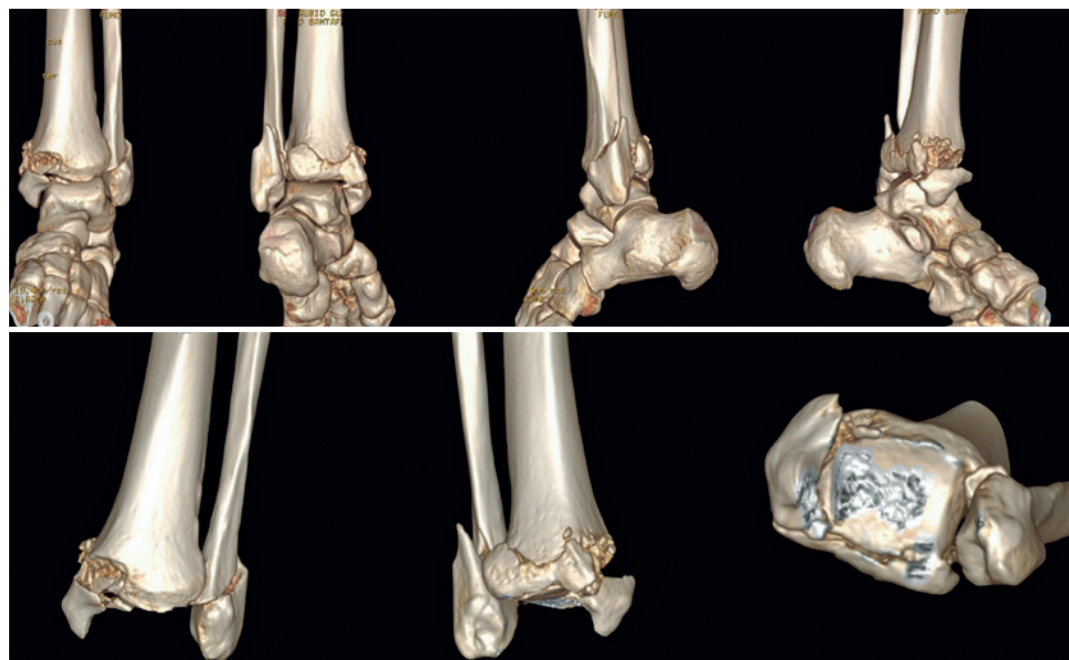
Three-dimensional computed tomography scan showing a trimalleolar fracture with detailed visualization of the fracture components.
